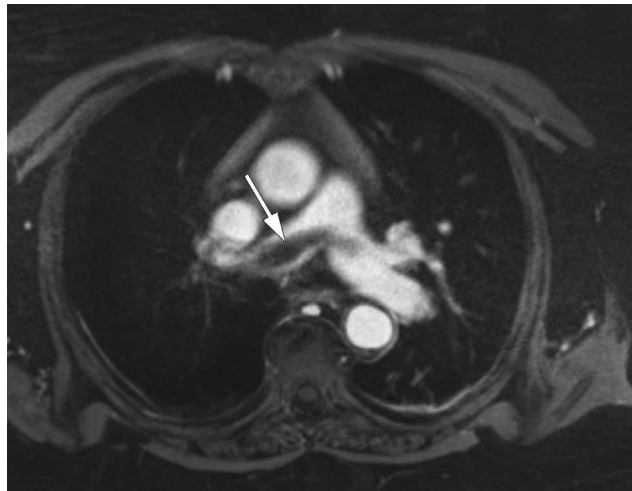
Acute pulmonary embolism (PE). Annotated. Chest. MRI. T1 weighted. Fat suppression. Contrast enhancement. Delayed phase. Axial plane. Motion-compensated sequence. There is a saddle PE (arrow). It is seen within the main pulmonary artery crossing over from its most prominent portion in the right pulmonary artery to the smaller portion seen in the left pulmonary artery.
